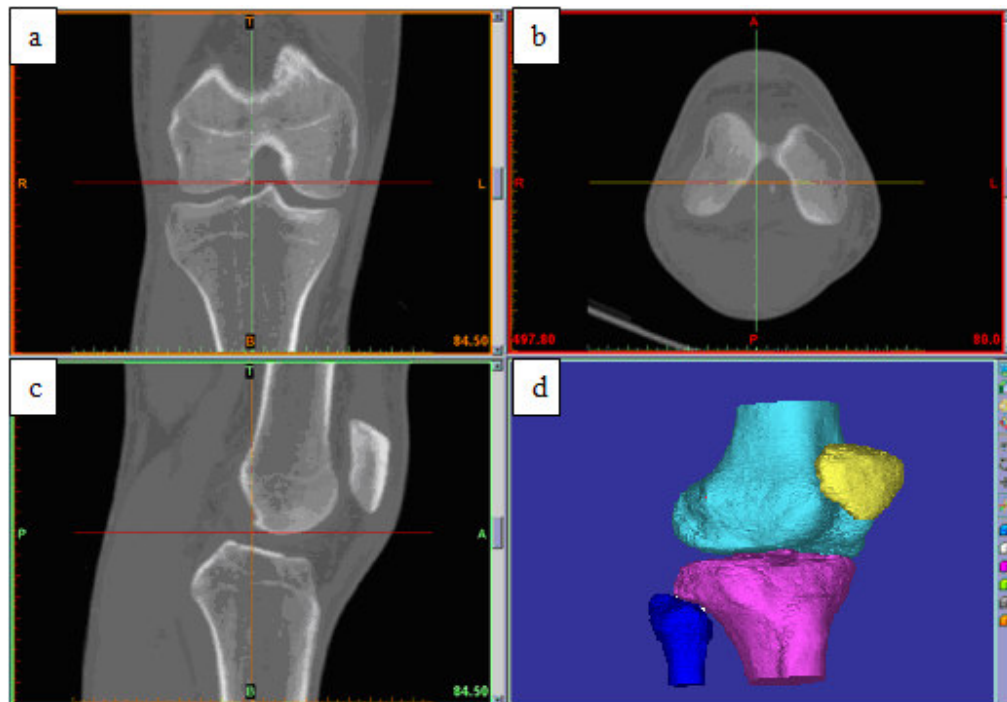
MIMICS user interface with imported CT scan:
